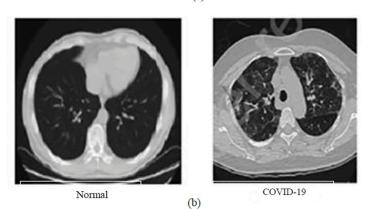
A sample of the used data (a) X-ray and (b) CT.
